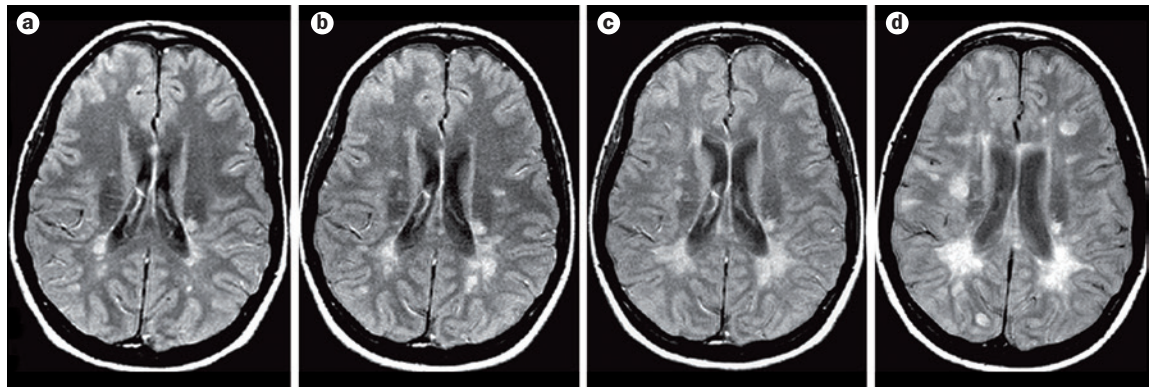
Serial MRI in a patient with relapsing–remitting multiple sclerosis. Proton-density weighted MRI scans obtained at a | baseline, and b | 1 year, c | 2 years and d | 3 years later. Disease progression can clearly be seen in the form of new and enlarging focal lesions over time, shown here as hyperintensities (white spots).
